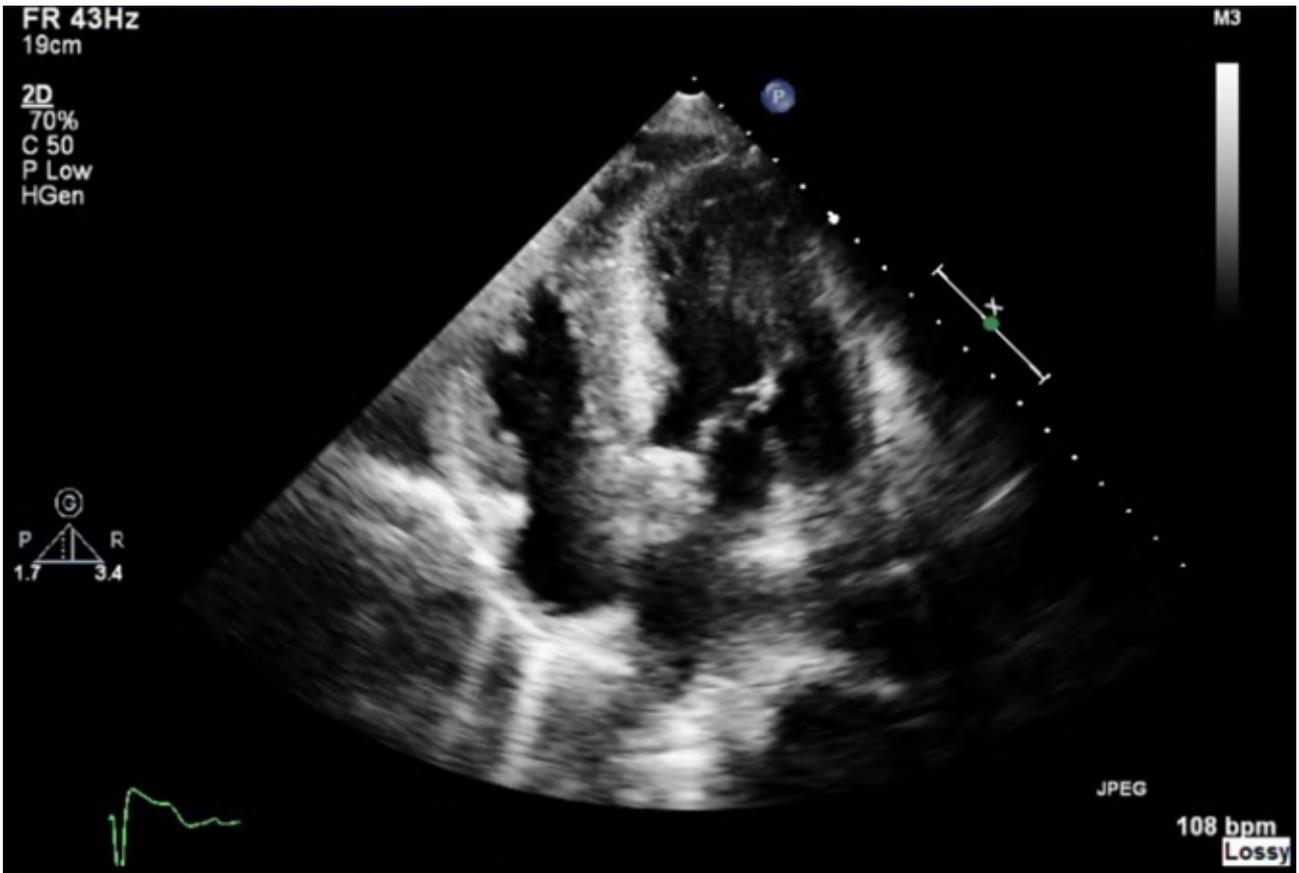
Echocardiographic appearance of cardiac amyloidosis. Four chamber view, increased biventricular wall thickness and interatrial septal thickness
